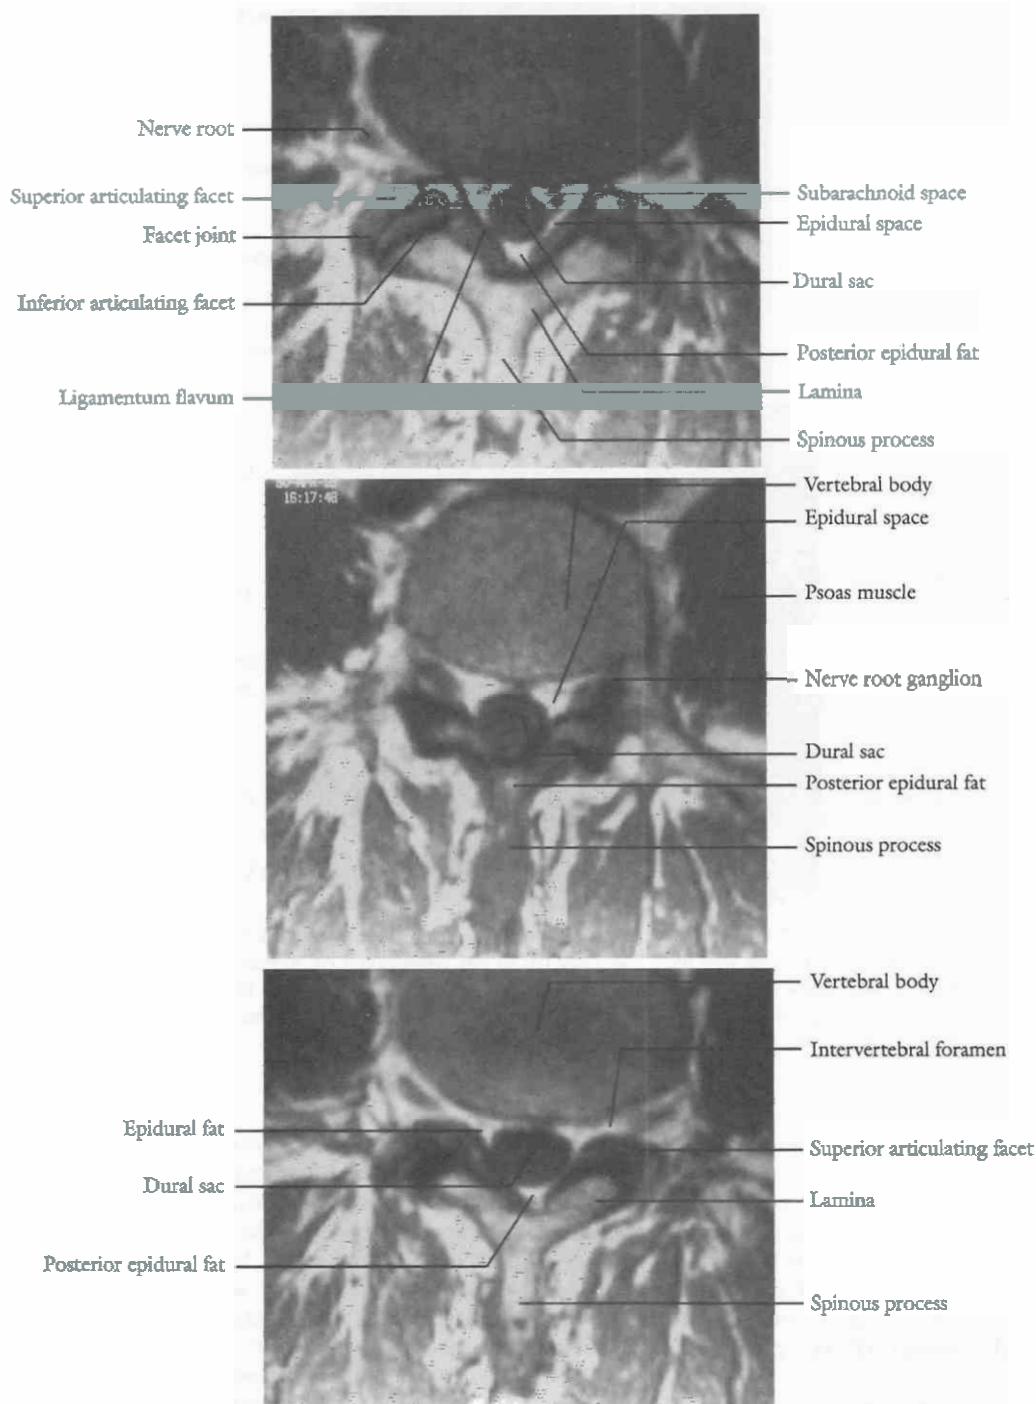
Top*, Axial T1 MRI through the facet joints. The ligamentum flavum, medial to the lamina, is seen bordering the posterior lateral aspect of the canal. The thecal sac is separated from the ligament by fat. *Center*, Axial T1 MRI scan through midportion of the vertebral body in the lumbar region. Fat with high signal intensity is seen anterior to the thecal sac and within the intervertebral foramen. The nerve root ganglion is seen inside the foramen. Dense cortical bone has lower signal intensity relative to the rest of the vertebral body. *Bottom*, Axial T1 MRI of fat in the epidural space helps to outline the thecal sac. Ligamentum flavum, which has a low-signal-intensity border, outlines the canal posterolaterally.
